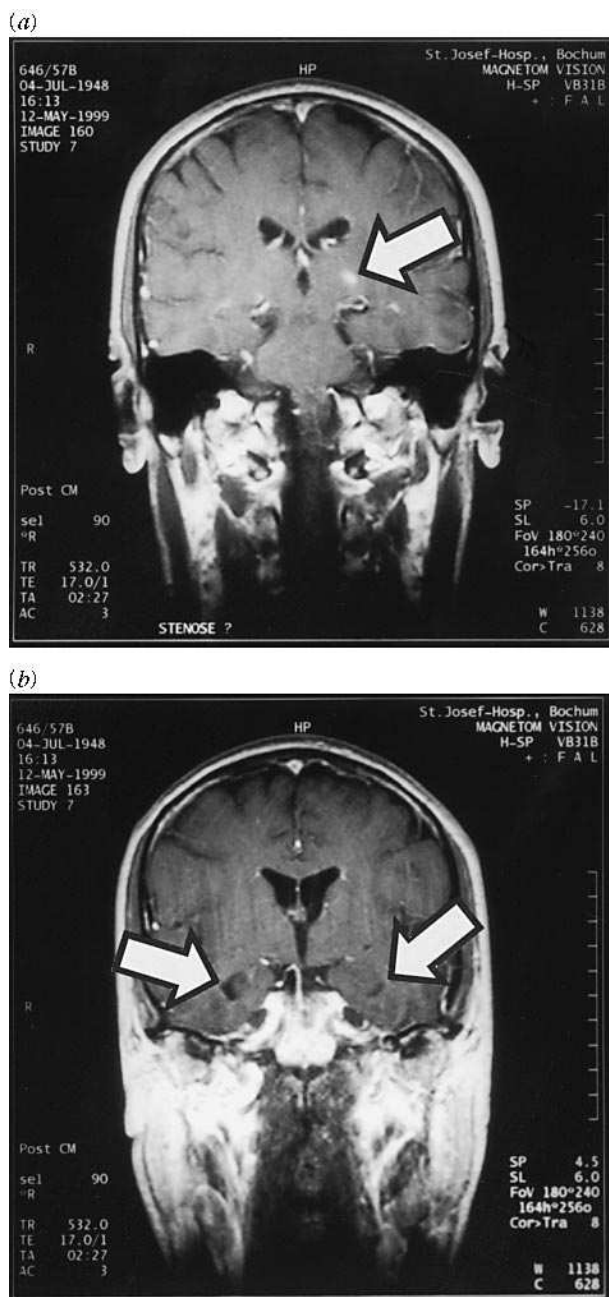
T1-weighted contrast-enhanced MRI scans showing (a) a left thalamic infarction (arrowed) and (b) a bilateral gliosis of unknown genesis in the left and especially the right amygdalar region (arrowed).
